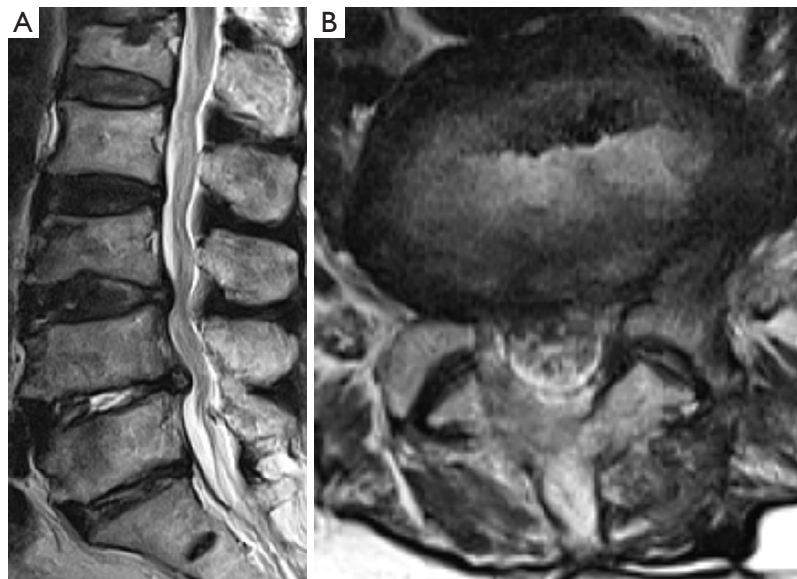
Postoperative sagittal (A) and axial (B) magnetic resonance images show the full decompression state without any abnormal findings.
